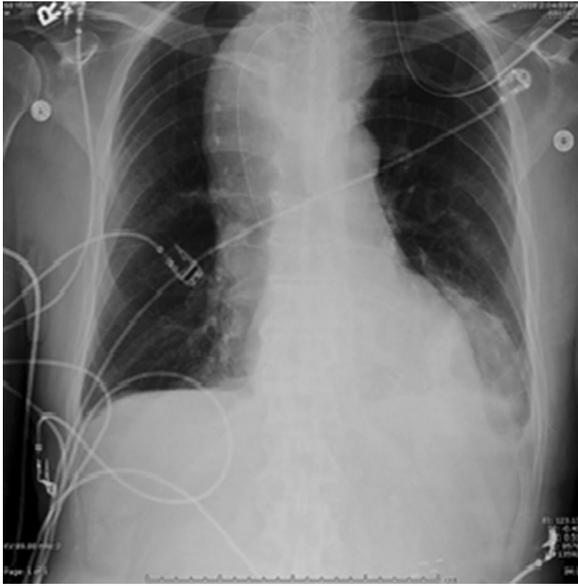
Chest radiograph demonstrating a widened mediastinum with the presence of a nasogastric tube reflecting the tortuous, dilated, and elongated esophagus. No gastric bubble is identified, a nonspecific sign that can be associated with achalasia
